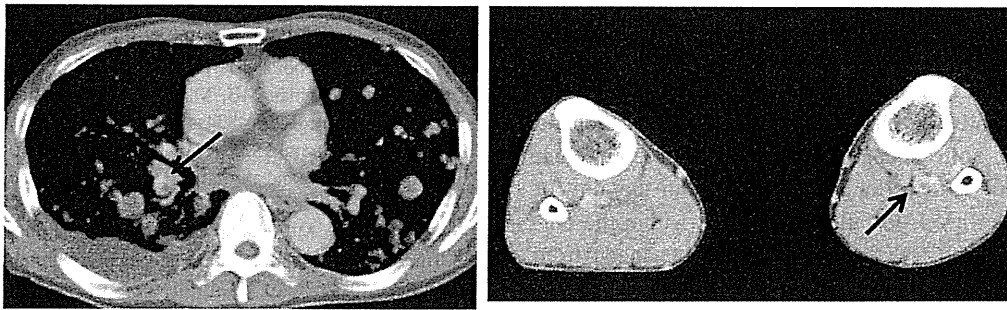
Enhanced CT of Case 3 revealed thrombus of the right pulmonary artery (A) and left popliteal vein (B) (arrow).
